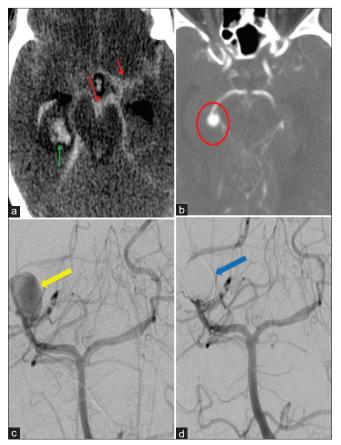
A 33-year-old female with decreased level of consciousness; noncontrast CT (a) demonstrates diffuse SAH in the prepontine cistern and the right Sylvian fissure (red arrows), in addition to intraparenchymal hemorrhage in the right temporal lobe (green arrow). On CTA (b), a 9 mm round aneurysm extending from the sidewall of the right P2/3 junction (red circle) is seen. DSA AP view pre coil embolization (c) shows the aneurysm (yellow arrow) and postembolization (d) complete occlusion with no flow at the coil pack (blue arrow).
